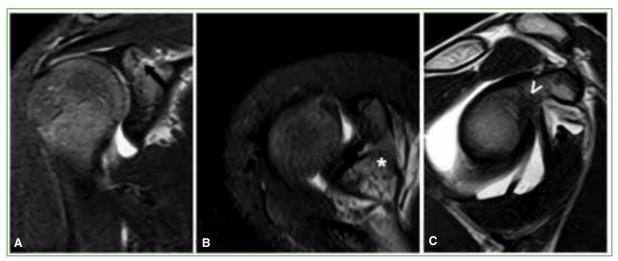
MRI of the right shoulder: coronal STIR (A), axial STIR (B), and sagittal T2 (C). The secondary ossification center of the coracoid (indicated by ↑, * and >, respectively) is seen extending toward the physis between the coracoid base and scapula, with signal intensity similar to the surrounding scapular bone.
